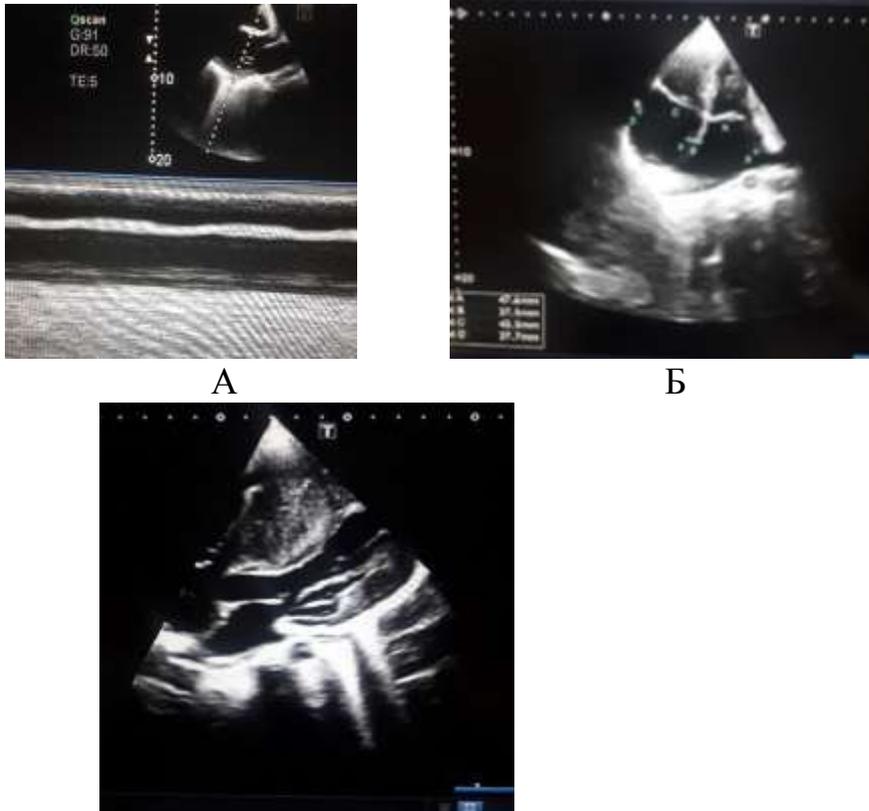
Echocardiogram in children with CMP. A - total hypokinesia of LV walls (Diagnosis: DCMP); B - dilatation of both atria (Diagnosis: RCMP); C- hypertrophy of interventricular septal walls (MVP) (Diagnosis: GCMP).
